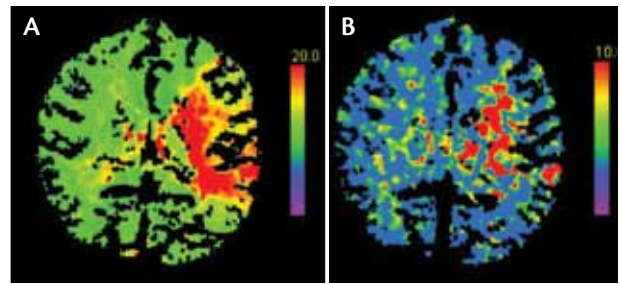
CT axial perfusion images showing the brain at risk from the acute stroke. Time to peak (A) and mean time to peak (B).
